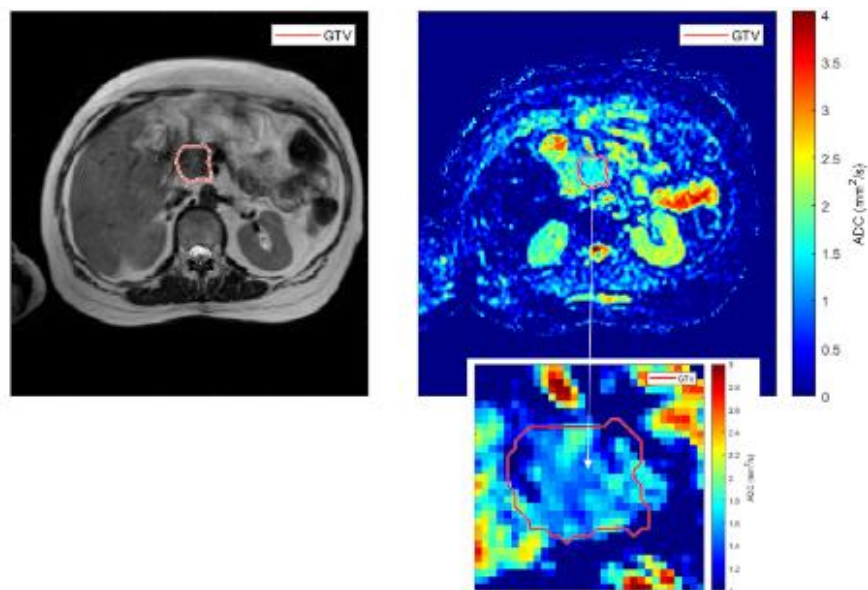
Example of a patient's pre-treatment scan along with scan from fraction 1 and 2 demonstrating the challenge of motion (a) and a comparison between a T2-weighted scan and a DWI scan (b).
